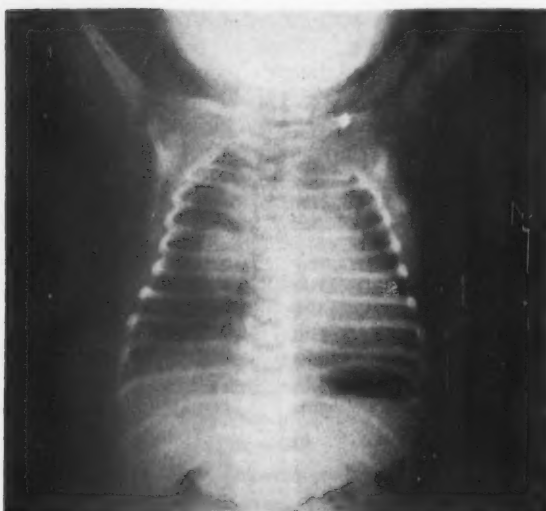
Posteroanterior roentgenogram showing right ventricular hypertrophy and enlarged pulmonary vessels.
